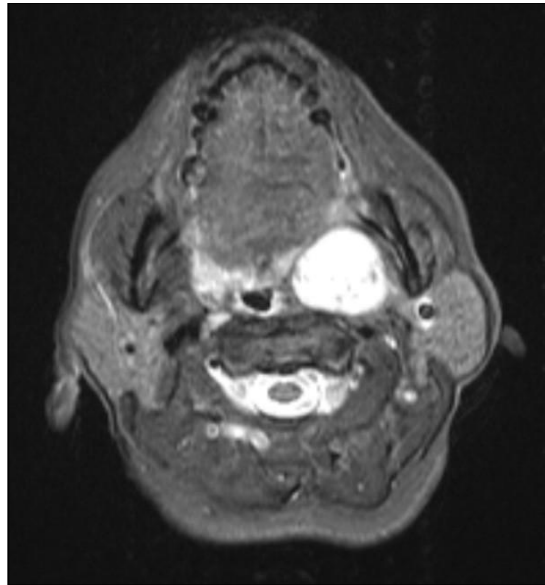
Contrast-enhanced MRI showing a well-circumscribed, heterogeneously enhancing lesion in the left parapharyngeal space, measuring $3.1 \times 3.1 \times 3.1 \text{ cm}^3$
